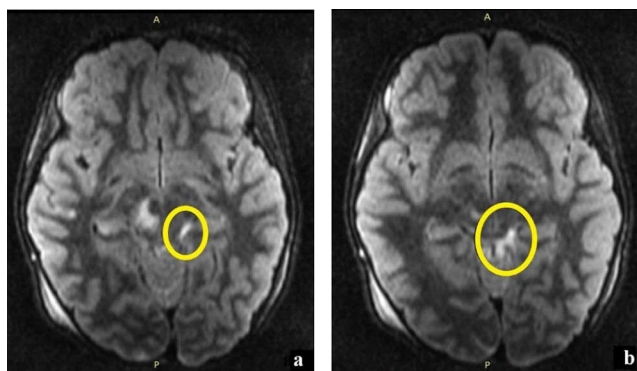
An 8-year-old patient, motor vehicle accident. (a and b) The left ambient cistern has a high-intensity FLAIR signal (yellow circle) suggestive of traumatic subarachnoid hemorrhage.
